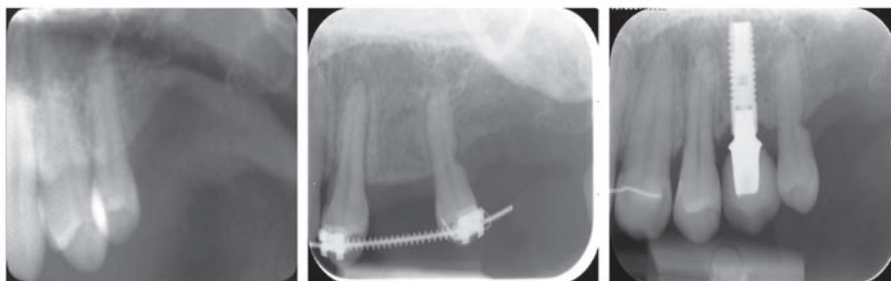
Periapical radiographs from baseline, retention and follow-up, subject 4. The distal lateral resorption seen at retention was more or less unchanged at follow-up.
